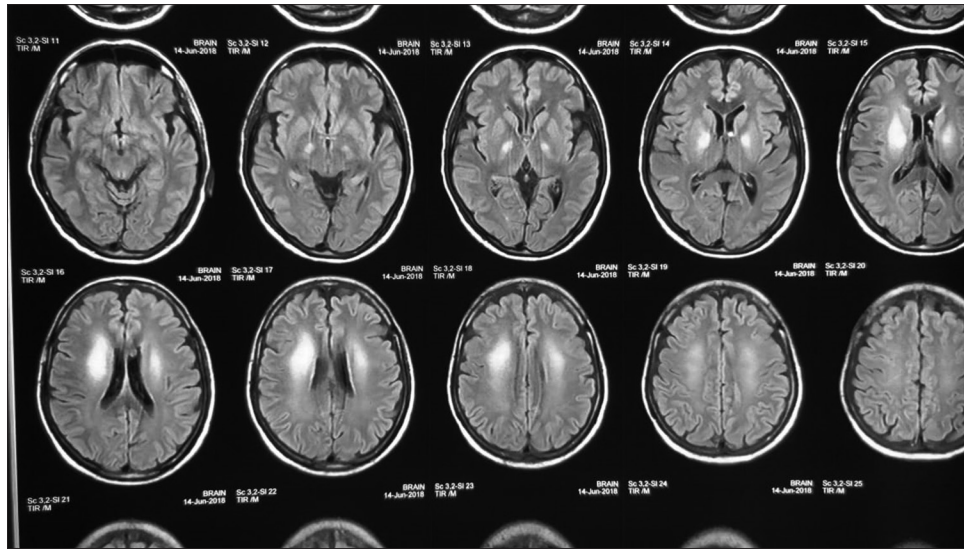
MRI brain showing symmetrical T2/FLAIR hyperintensities are noted in bilateral cerebral peduncles along the cortico- spinal tract, mid pons, bilateral cerebellar peduncles, bilateral cerebellar parenchyma with subtle diffusion restriction predominantly in the pons and centrum semiovale
